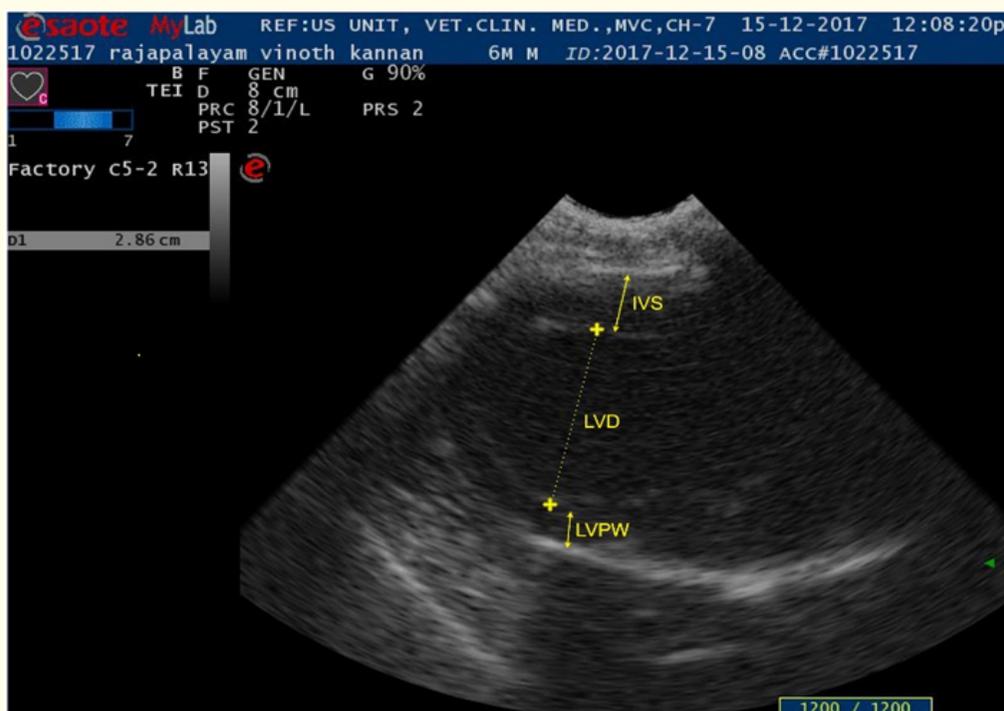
Two dimensional echocardiographic image-Right long axis view of left ventricle. IVS: Interventricular Septum; LVD: Left Ventricle Diameter; LVPW: Left Ventricular Posterior Wall.
